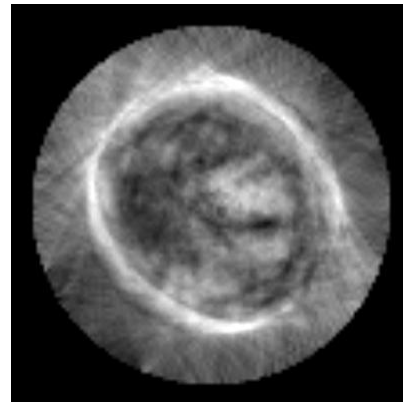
Comparison of ultrasound attenuation images reconstructed using *in vivo* breast data for Patient A and the amplitude decay, spectra ratio, and complex signal energy ratio methods. Image in (a) is the corresponding sound-speed reconstruction.
